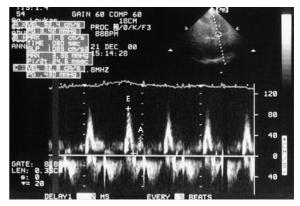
Transmitral Doppler flow consistent with restrictive physiology (E wave=91.6 cm/s, A wave=32.8 cm/s, deceleration time=80 ms, E/A=3/1).
